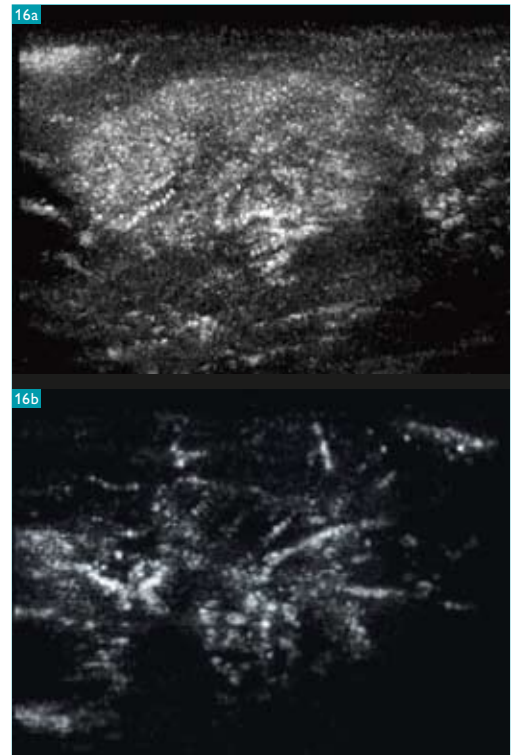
Contrast-enhanced ultrasound can show the differences in microvascular morphology between benign and malignant lesions, improving the differential diagnosis of solid breast nodules. Images obtained with Optison® and MVI.
